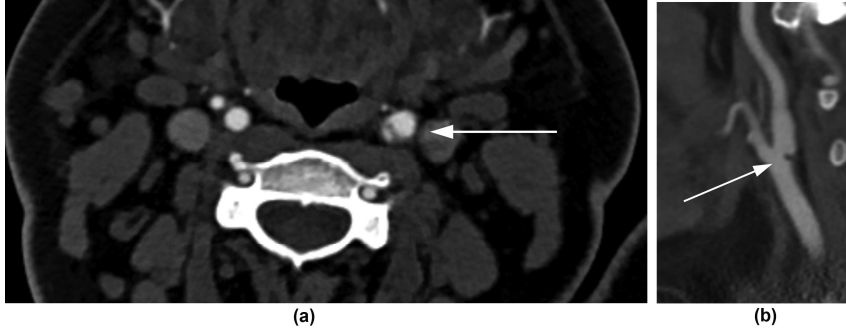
CTA of a thrombotic carotid bulb, axial (a) and sagittal (b) images (Image from [20]). The white arrow indicate the thrombotic bulb extending from the outer wall into the lumen.
